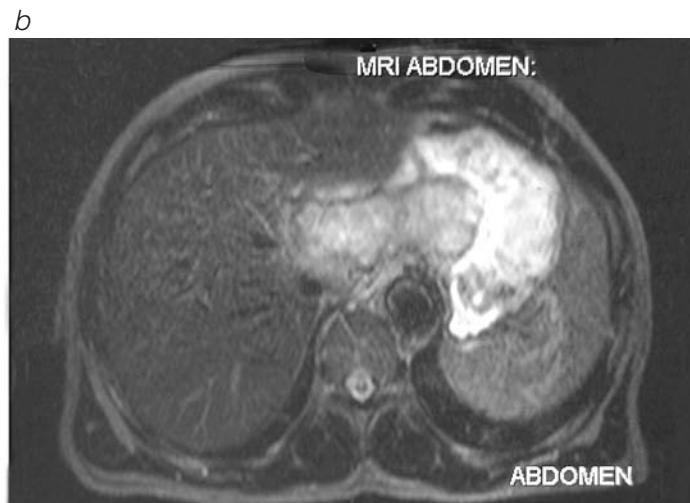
(a) Gadolinium-enhanced, T_1 -weighted MRI shows a large mass that appears dark and well-circumscribed in comparison with the normal-appearing enhanced liver and spleen. This abnormal mass clearly contains some fluid. The fluid-filled stomach also appears dark. (b) T_2 -weighted MRI of the same patient details subtle inhomogeneities characteristic of a malignant mass (less organized appearance with an enhanced necrotic component). Subsequent biopsy showed this mass to be a poorly differentiated adenocarcinoma from recurrent colon cancer.
